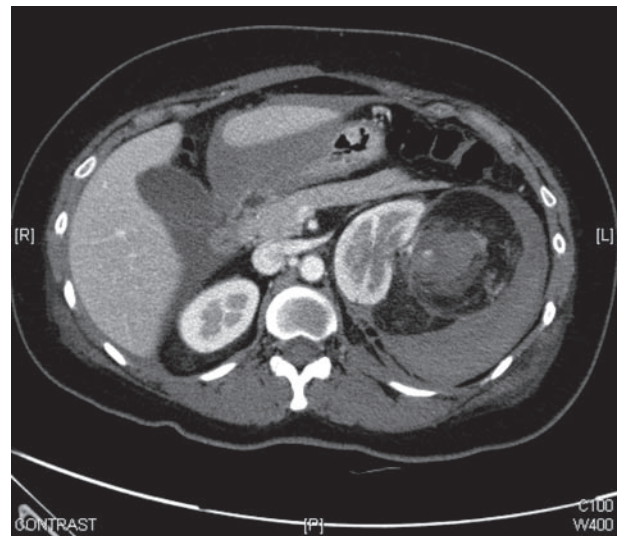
Post contrast CT abdomen showing a fat containing lesion in the left kidney with haemorrhage compatible with angiomyolipoma (7 cm x 8 cm x 10 cm).
